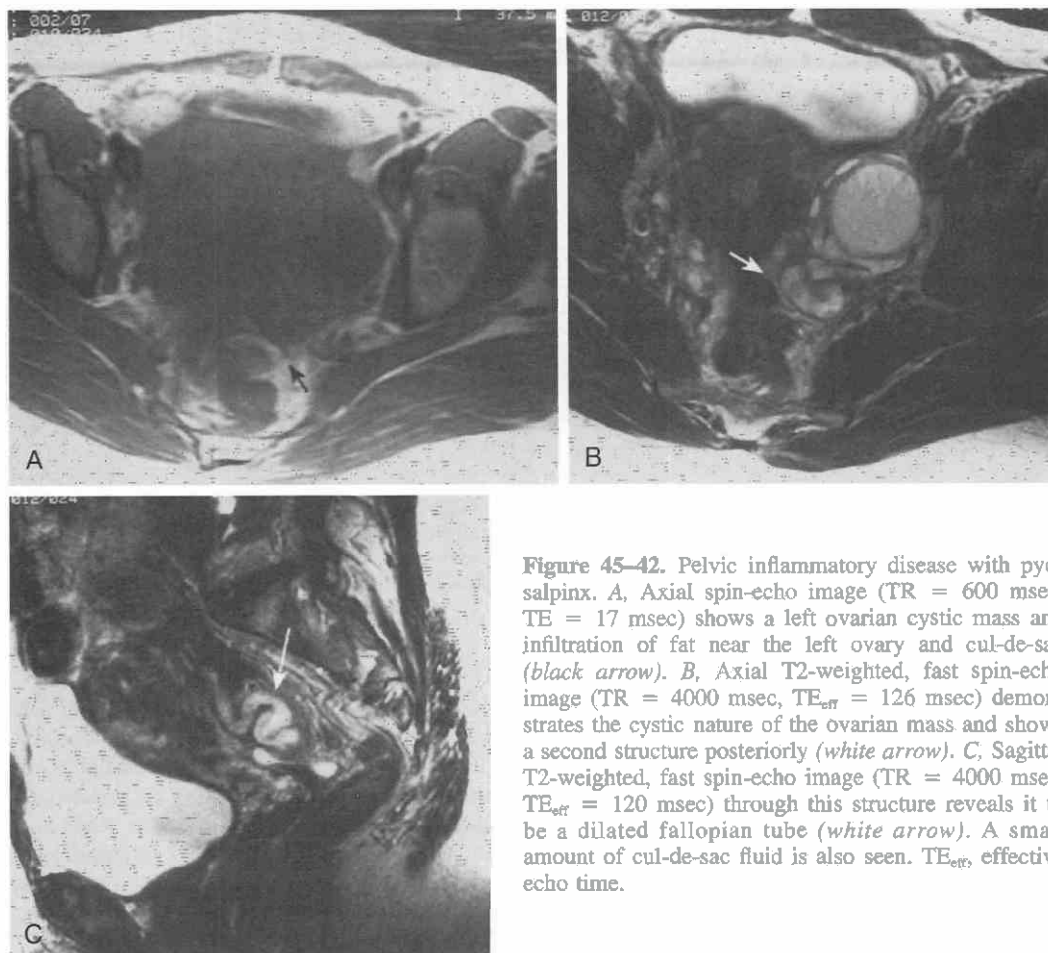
Pelvic inflammatory disease with pyosalpinx. *A*, Axial spin-echo image (TR = 600 msec, TE = 17 msec) shows a left ovarian cystic mass and infiltration of fat near the left ovary and cul-de-sac (black arrow). *B*, Axial T2-weighted, fast spin-echo image (TR = 4000 msec, TE_{eff} = 126 msec) demonstrates the cystic nature of the ovarian mass and shows a second structure posteriorly (white arrow). *C*, Sagittal T2-weighted, fast spin-echo image (TR = 4000 msec, TE_{eff} = 120 msec) through this structure reveals it to be a dilated fallopian tube (white arrow). A small amount of cul-de-sac fluid is also seen. TE_{eff}, effective echo time.
